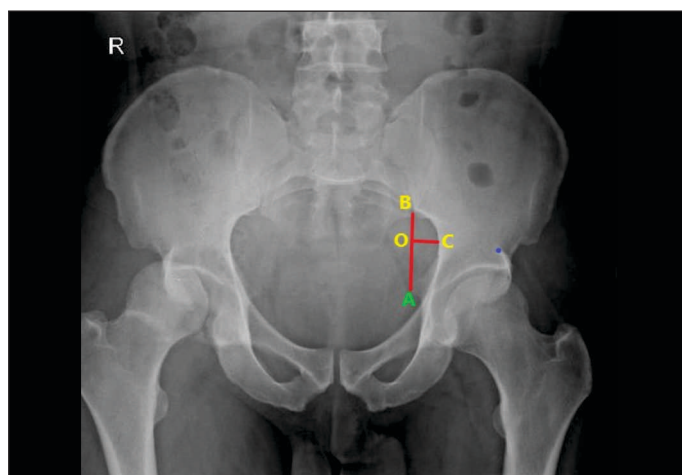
Antero-posterior pelvic radiograph showing measurement of GSN. A – tip of the ischial spine, B – Piriformis tubercle, AB –Width, OC- Depth, C- deepest point of the GSN, OB- posterior segment.
